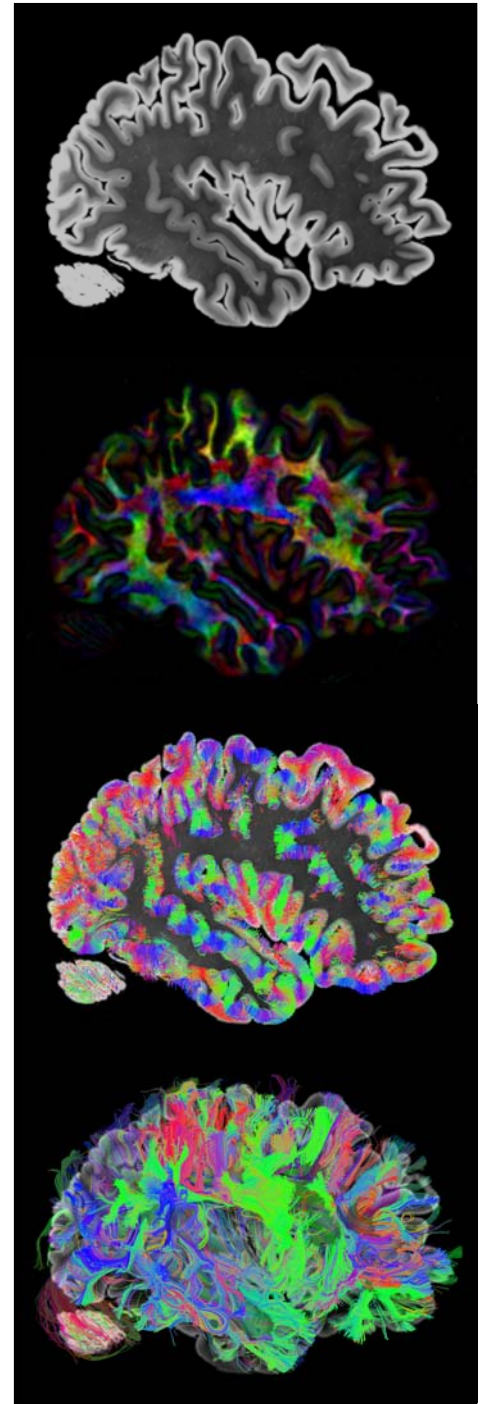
Sagittal view of hemisphere. From top to bottom: mean diffusion-weighted image; color FA image; short fibers only overlaid on DWI image; long fibers only overlaid on DWI image.
